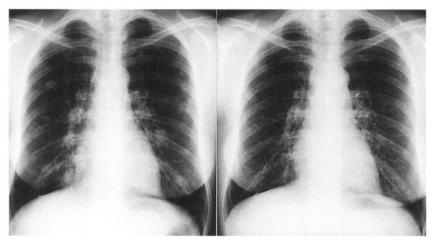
Left photograph shows multiple lung tumors in patient number 7 on the day of admission. The chest x-ray (right) after HDCT shows no abnormal tumor shadows.
